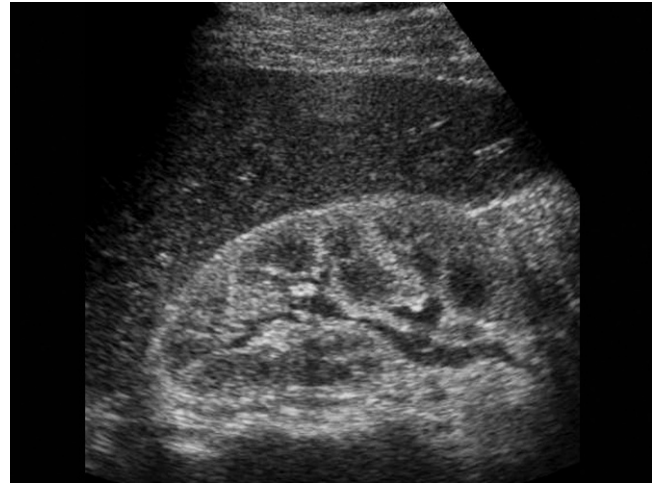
Two-month follow-up ultrasound of the right kidney, which is now small kidney, and increased cortical echogenicity. This is a case of treated lymphoma.
